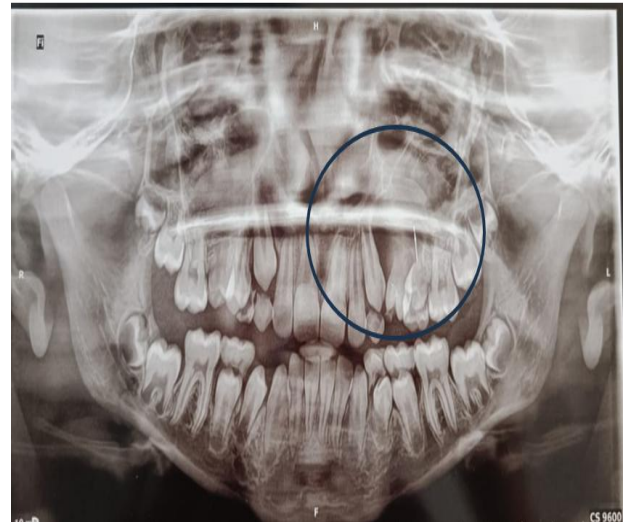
Preoperative orthopantomogram showing radiolucent lesion in the left maxillary region.
